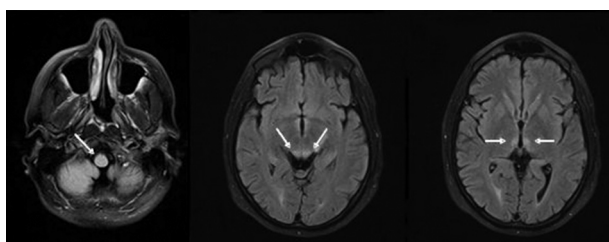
MRI (FLAIR Sequences) Consistent With the Diagnosis of WE
